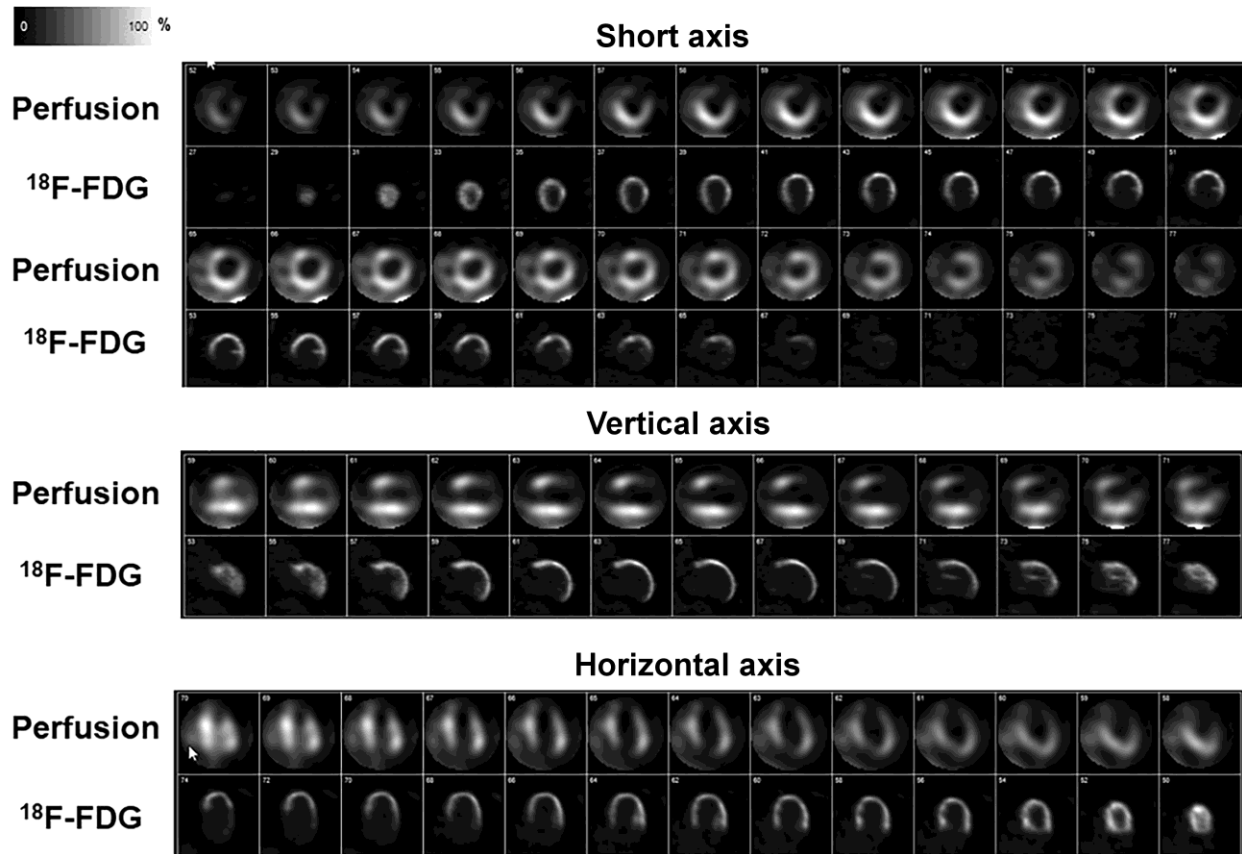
Rest myocardial perfusion with SPECT/CT images with ^{99m}Tc-tetrofosmin and ¹⁸F-FDG PET/CT in a patient with dilated ischemic cardiomyopathy, demonstrating a “mismatch”.
